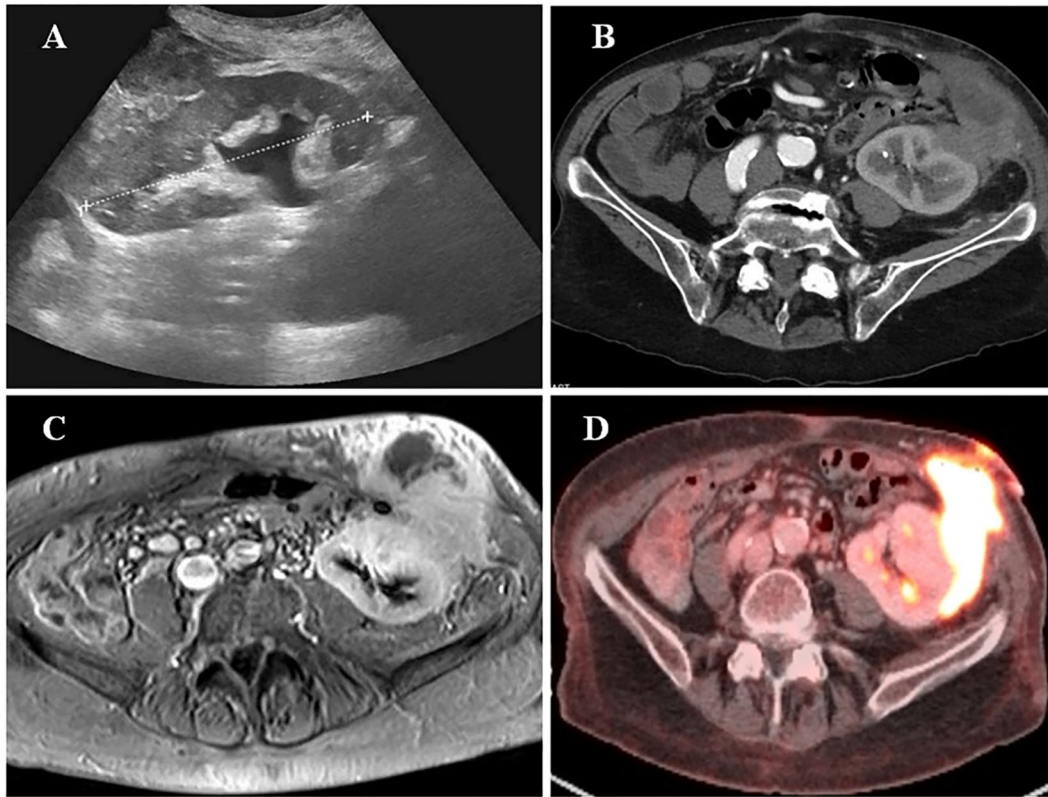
(a) Ultrasound at first presentation. (b) Contrast-enhanced CT, venous phase: according to initial protocol strong resemblance to large abdominal wall hematoma adjacent to the left oblique abdominal wall musculature, bordering the renal allograft. (c) MRI T1 TFE sequence: Mixed hyper- and hypo-intense signal on the T1- and T2-weighted images. Diffuse, predominantly late, enhancement of the lesion with heterogeneous, strand-like enhancement of the subcutaneous component. Diffuse, fairly homogeneous, pathological diffusion restriction throughout the entire lesion. On imaging suspect for sarcomatous origin, and fast evolutive in comparison to CT (b). (d) Intensely hypermetabolic mass in the left abdominal wall, extending to the skin, adjacent to the descending colon and the renal allograft, and appears to be connected to the haemorrhagic cyst interstitial in the renal allograft: based on imaging preference for malignant lesion.
